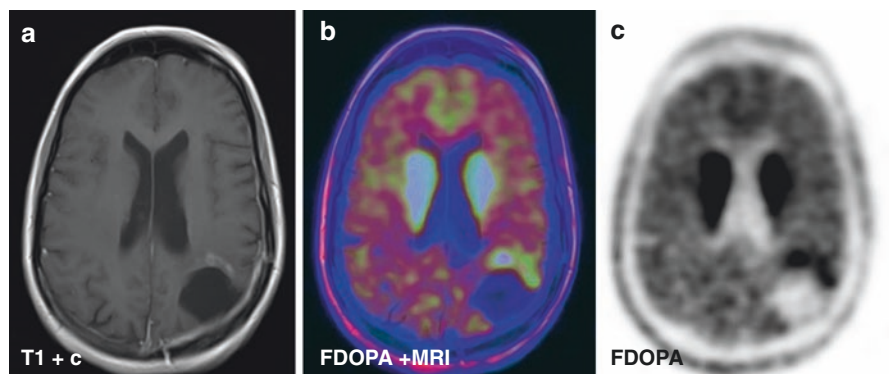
Example of FDOPA PET follow-up in a patient with a glioblastoma. Follow-up imaging of a 26-year-old female glioblastoma patient, after surgical resection and chemoradiotherapy. Gadolinium-enhanced T1-weighted MRI (left image) 5 months after surgery was suggestive of tumor progression (white arrow). FDOPA PET was performed for other reasons (middle and right images) and demonstrated increased uptake (white arrows), also suggesting tumor progression. Co-registration of FDOPA PET and MRI (middle image) showed increased uptake at the site of enhancement on MRI. Subsequent follow-up MRI later showed further growth, confirming this case of tumor progression. The patient deceased within a year after the FDOPA PET scan
